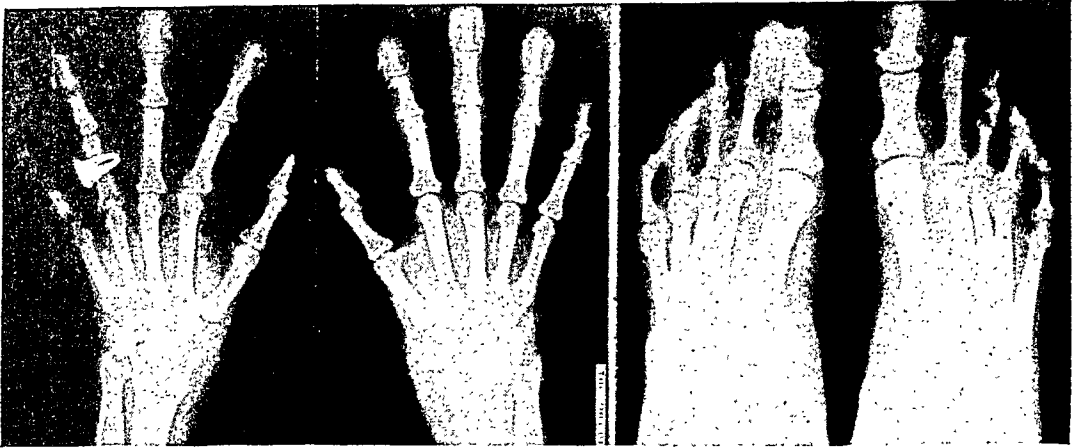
Roentgenograms of the hands and feet present an interesting contrast between the terminal phalanges of the feet and those of the hands. The distal portions of the radius and ulna show an increased diameter. Soft tissue hyperplasia is evident.
